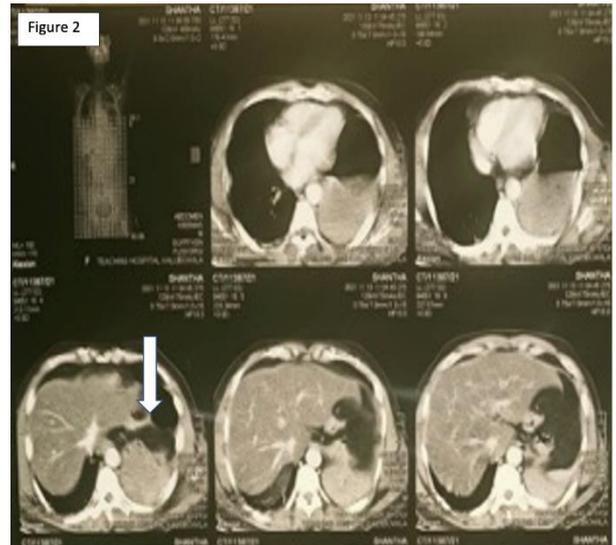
Cross-sectional CECT images showing left diaphragmatic defect with transthoracic gastric herniation
